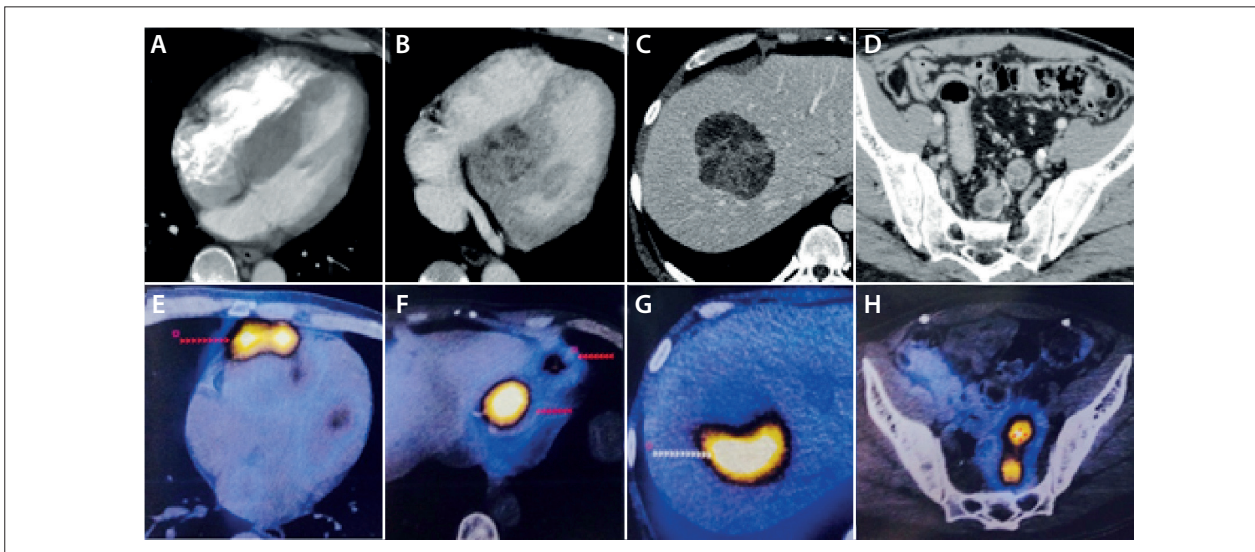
Thoracic and abdominal CT (A-D) and SPECT-CT scan with octreotide (E-H). A and B: Multiple cardiac metastatic lesions. C: Isolated hepatic metastatic lesion. D: Pelvic lymphadenopathies adjacent to the rectum. E and F: Cardiac metastatic lesions with intense uptake of octreotide. G: Hepatic metastatic lesion with intense uptake of octreotide. H: Pelvic lymphadenopathies with intense uptake of octreotide.
